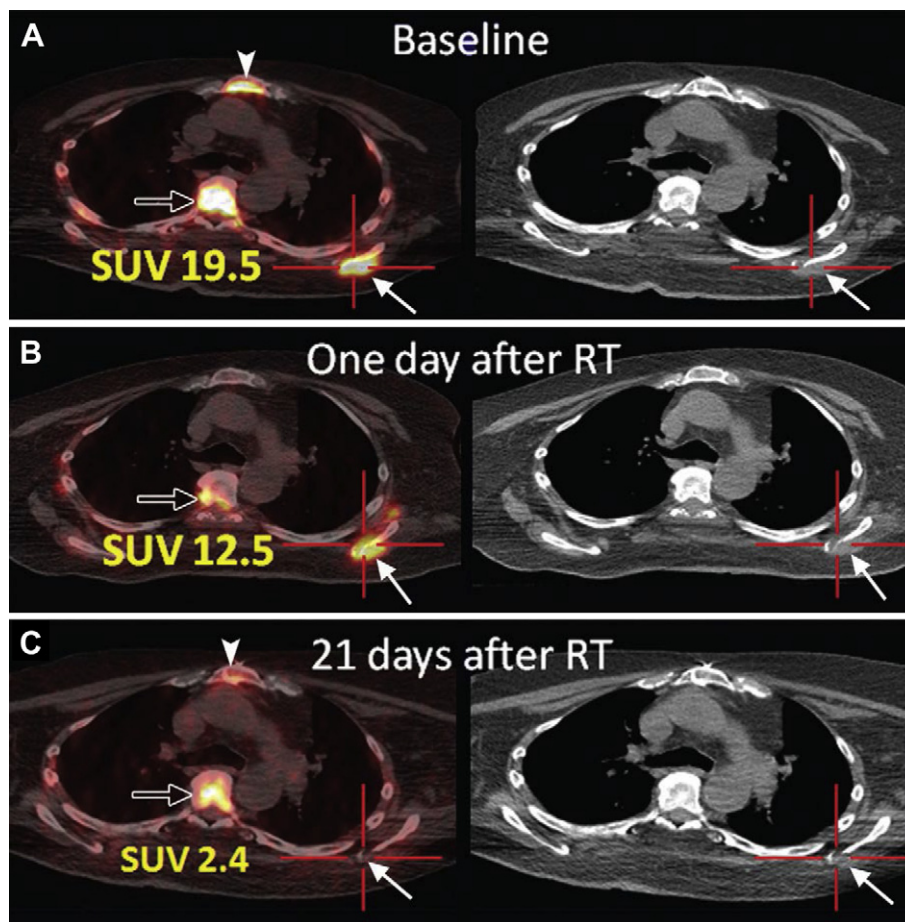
Images from PET/CT performed by using ^{18}F L-thymidine (FLT) in a 70-year-old man with widely metastatic squamous cell cancer of the oropharynx. Images were acquired, *A*, before, *B*, 1 day after, and, *C*, 21 days after single dose fraction (2400 cGy) radiation treatment (RT) of a metastatic lesion in the left scapula (solid arrows). There is resolution of uptake at the tumor site in the left scapula. Physiologic FLT uptake is seen in bone marrow of the thoracic spine (open arrow) and sternum (arrowhead). SUV = standardized uptake value. (Reprinted from Hricak H. Oncologic imaging: a guiding hand of personalized cancer care. *Radiology*. 2011 Jun; 259(3):633–640).
